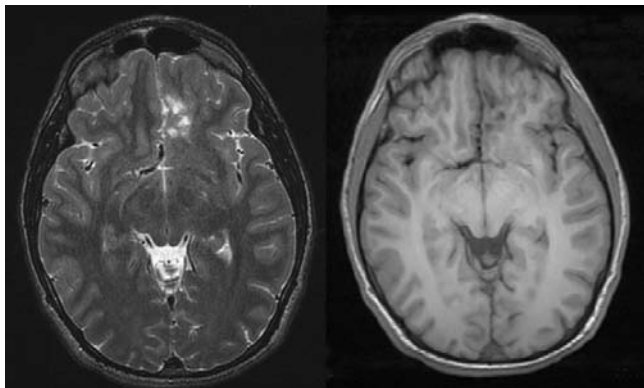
A 16-year-old with pathologically confirmed left mesial frontal dysplasia. T2-weighted sequence on left, T1-weighted sequence on right. The lesion did not enhance with contrast. For MRI, right image is left brain.
